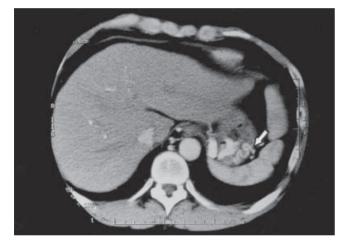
Short gastric vein (*arrow*), as the inflowing vessel, was detected with CT
